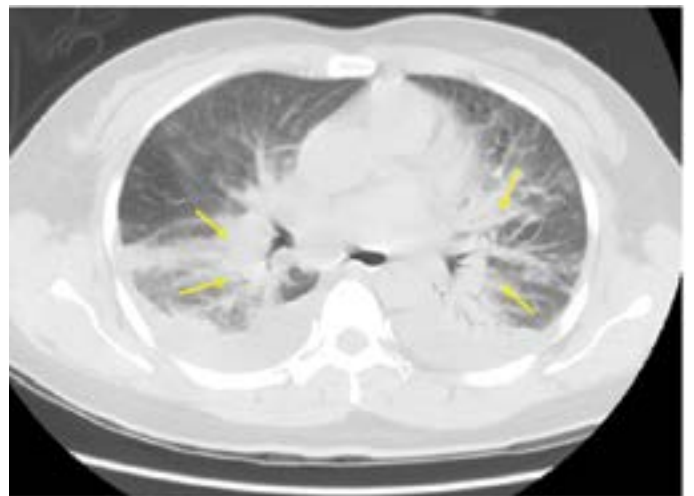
Computed tomography of chest shows bilateral pneumonia.
